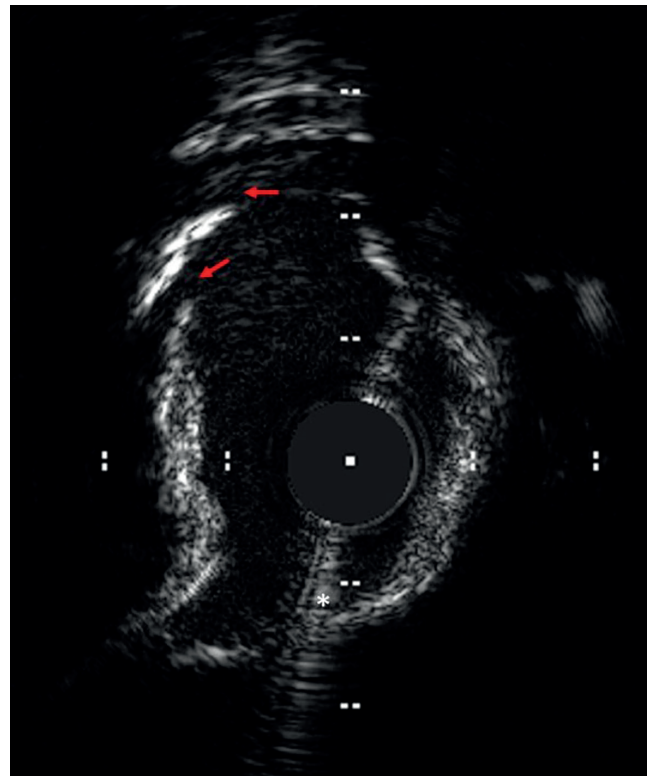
Calcification fractures (red arrows), wire artifact (white asterisk) – intravascular ultrasound
